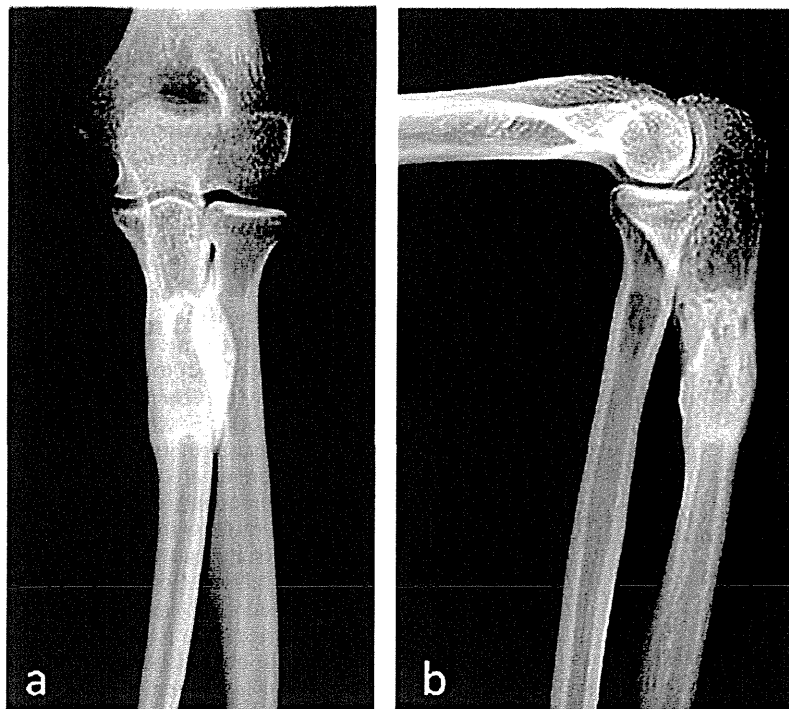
Anteroposterior (a) and lateral (b) plain radiographs after 3.5 years of surgery, showing complete graft incorporation and no recurrence.
